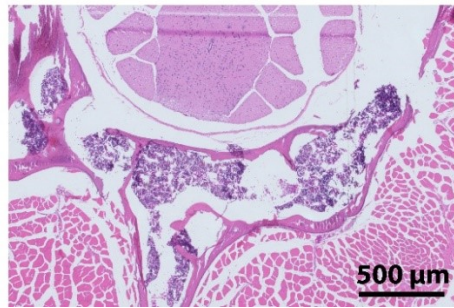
Post-mortem analysis of FDG avid areas suspected to be metastatic disease. The cortex, osseous body of the bone tissue and surrounding soft tissue in these areas did not show any evidence of metastatic tumor deposits..
